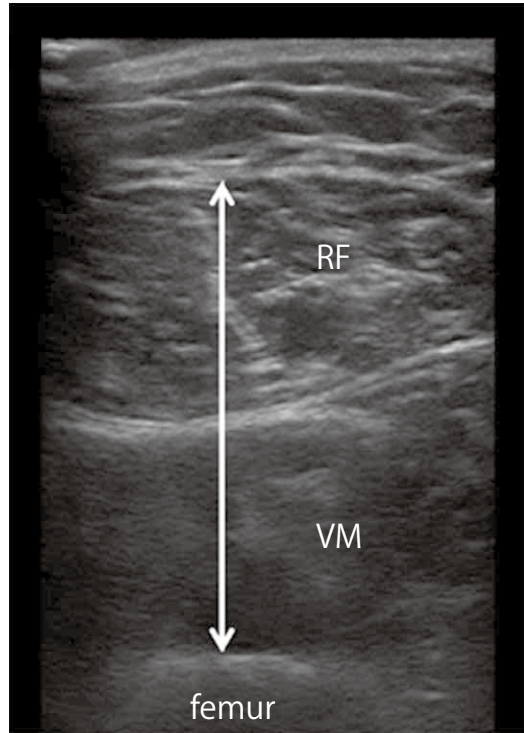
Ultrasound appearance of the quadriceps femoris muscle (QF)
